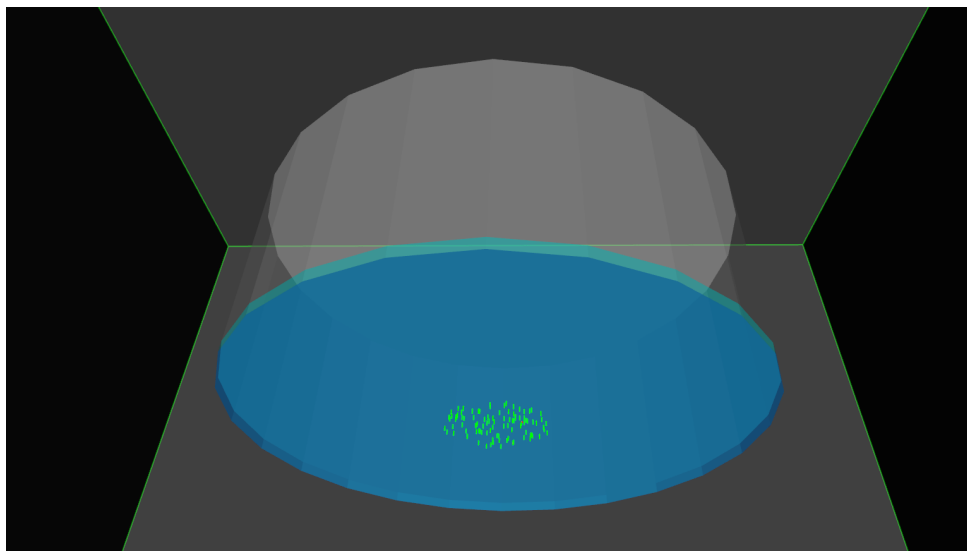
Visualization of the flask irradiation. The gray cylinder is the cell flask, which is filled with a water substrate (bottom of flask). Generated x-rays strike the flask from below.
